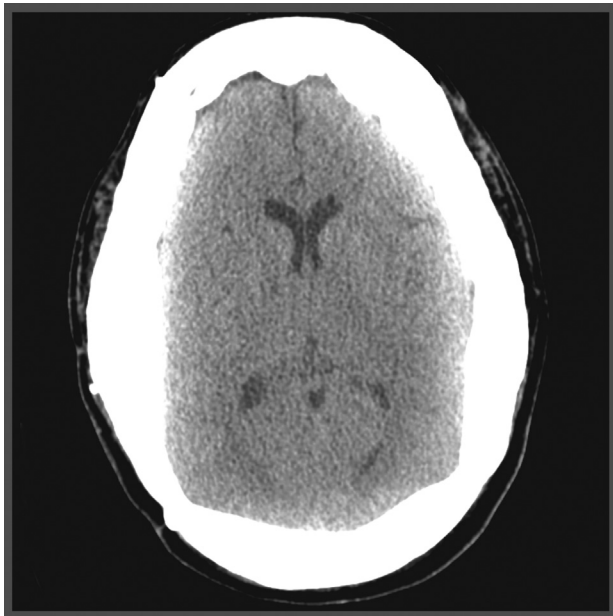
Preoperative computed tomography (CT) scan. Preoperative CT scan of the head showing diffuse hyperostosis and sclerosis of the calvarium. Effacement of underlying sulci was noted.
